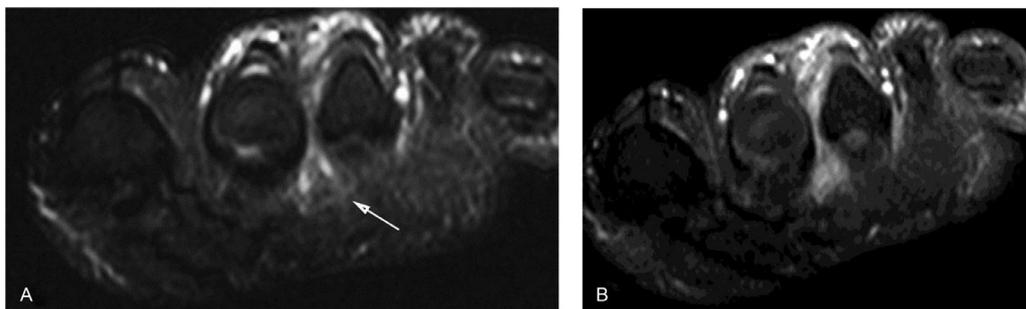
Morton's neuroma. (A) Coronal short-axis fat saturated T2WI shows a hypointense, lobulated, and solid mass between the second and third metatarsal heads (white arrow). (B) Coronal short-axis fat saturated postcontrast T1WI shows diffuse contrast enhancement. T1WI, T1-weighted images; T2WI, T2-weighted images.
